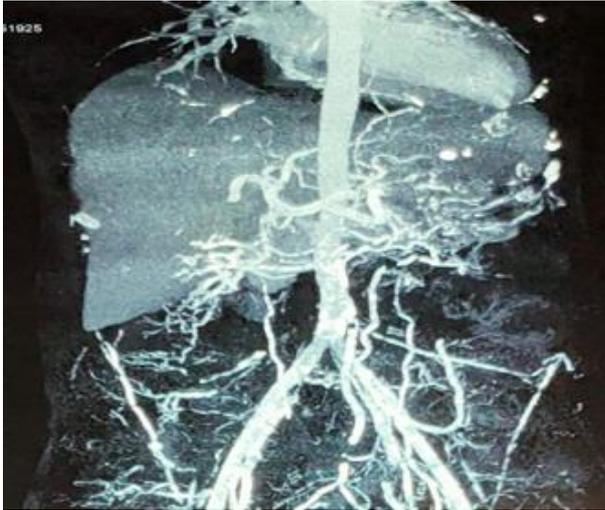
Coronal and sagittal view of abdominal CT scan showing extensive dense circumferential calcifications of the wall of the abdominal aortas and its branches (hepatic artery, celiac axis, superior mesenteric artery, inferior mesenteric artery), common iliac artery, external iliac artery and femoral artery.
